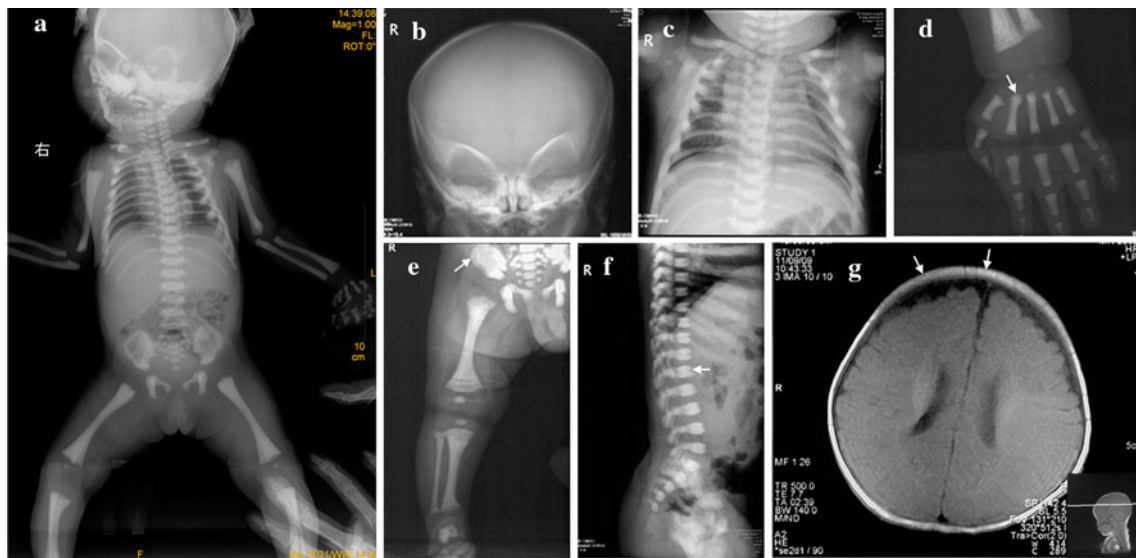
a Skeleton of the sister showing increased bone density. b Skull (b) and chest (c) of the brother showing sclerotic changes in the base of the skull, dense mastoid and small pituitary fossa, the clavicle, ribs, and scapula bones. X-ray film of the right hand (d) and leg (e) of the brother showing sclerosis of carpal bones, phalanges, and long bones resulting in obliteration of the marrow cavity and the “bone in bone”
